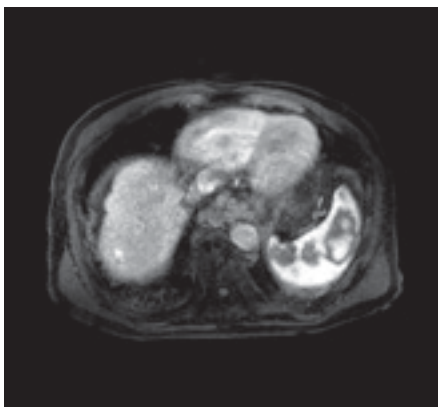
Arterial-phase image of gadoxetic acid-enhanced MRI.
